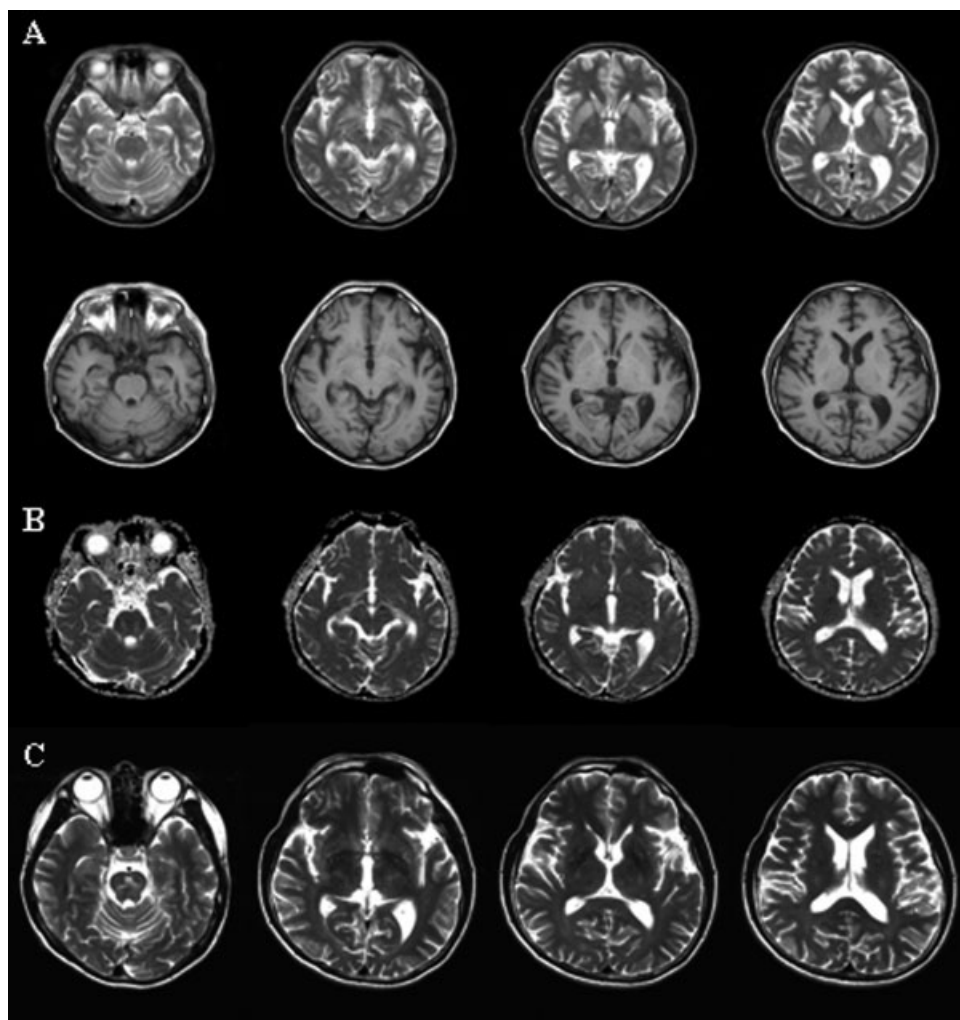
A: Brain MRI performed on the fifth day after onset of Parkinsonism revealing symmetrically increased signal intensity in the putamen and caudate nucleus on T2-weighted imaging, with isointensity on the T1-weighted image, and without signal change in the pons. B: The ADC of the DWI was normal. C: The follow-up MRI at 7 months revealed significant resolution of the basal ganglia lesion on T2-weighted imaging, but with signal change in the central pons.
